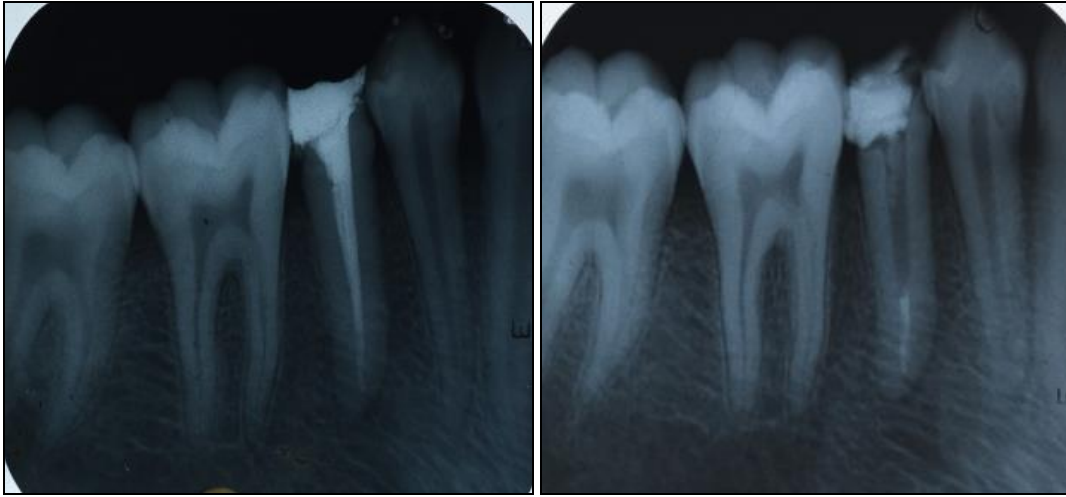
a) Intraoral preoperative radiograph, b) Radiograph showing post space preparation
